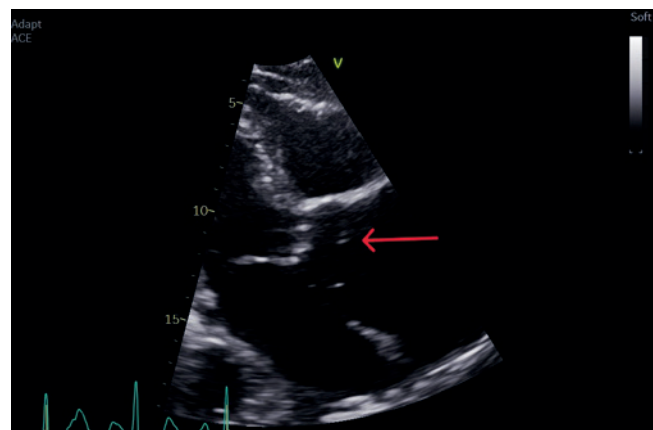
Parasternal long axis zoom showing intimal flap
